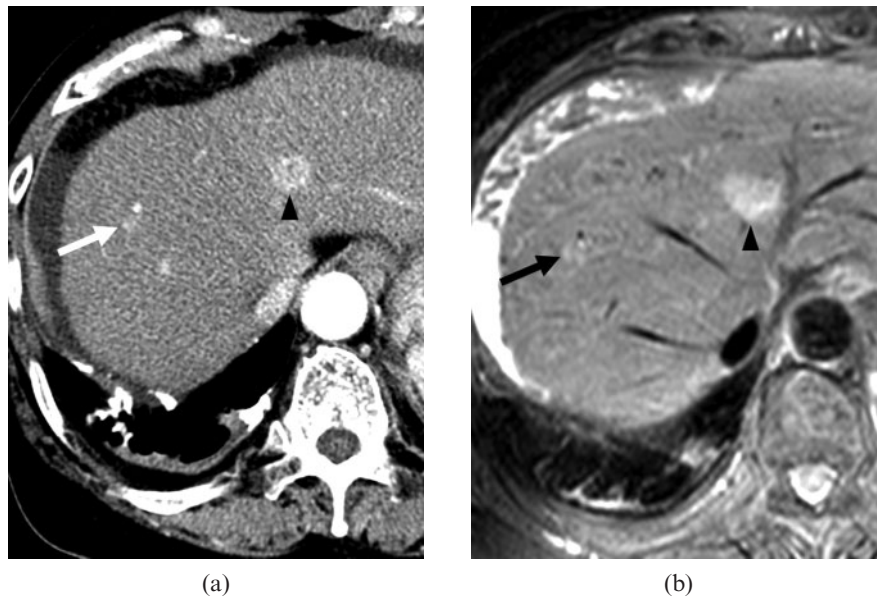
A 64-year-old female with a dysplastic nodule in segment VIII and a hepatocellular carcinoma (HCC) in segment IV. The lesions were confirmed by a total hepatectomy with liver transplantation. (a) Contrast-enhanced CT scan obtained on arterial phase shows a hypervascular nodule of 0.9 cm diameter (arrow) in segment VIII and a hypervascular nodule of 1.8 cm diameter in segment IV (arrowhead). On contrast-enhanced CT scan obtained on equilibrium phase at the same level as (a), the nodule in segment VIII showed no washout pattern, as opposed to the nodule in segment IV, which did show a washout pattern (not shown). All observers interpreted the nodule in segment VIII as an arterioportal shunt, and the nodule in segment IV as HCC. (b) On T_2 weighted MR image, two nodules in segments VIII (arrow) and IV (arrowhead) show hyperintensity. (c) Gadoteric acid-enhanced arterial phase MR image shows two hypervascular nodules in segments VIII (arrow) and IV (arrowhead). (d) Gadoteric acid-enhanced 3-min late phase MR image shows two nodules with a washout pattern in segments VIII (arrow) and IV (not shown). (e) Gadoteric acid-enhanced hepatobiliary phase MR image shows two hypointense nodules in segments VIII (arrow) and IV (not shown). All observers interpreted two nodules as HCCs.
